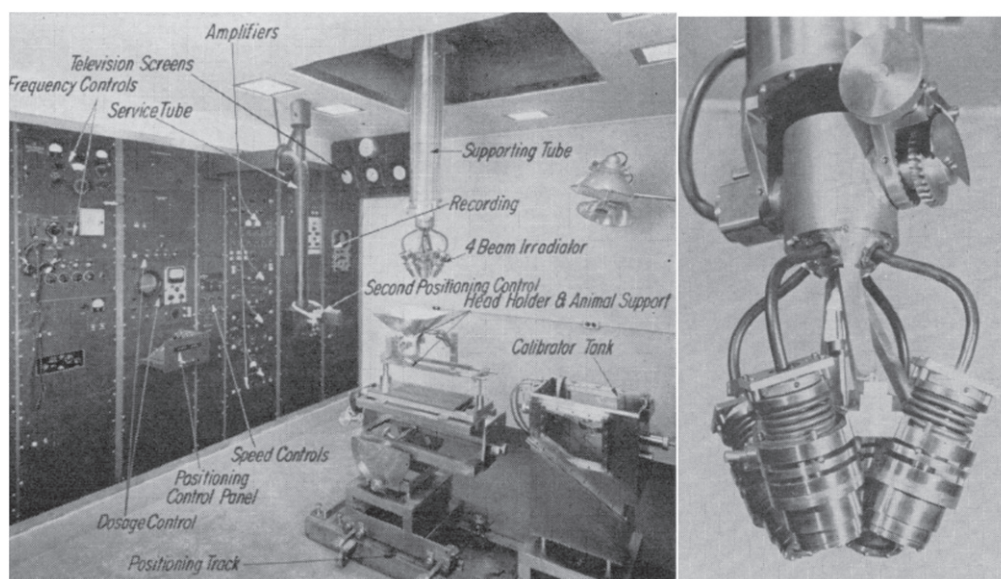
Experimental US sonication apparatus used by the Fry brothers *et al* in the 1950's Credit: W J and F J Fry 1960 Fundamental neurological research and human neurosurgery using intense ultrasound *IRE Trans. Med. Electron.* Copyright IEEE 1960.
